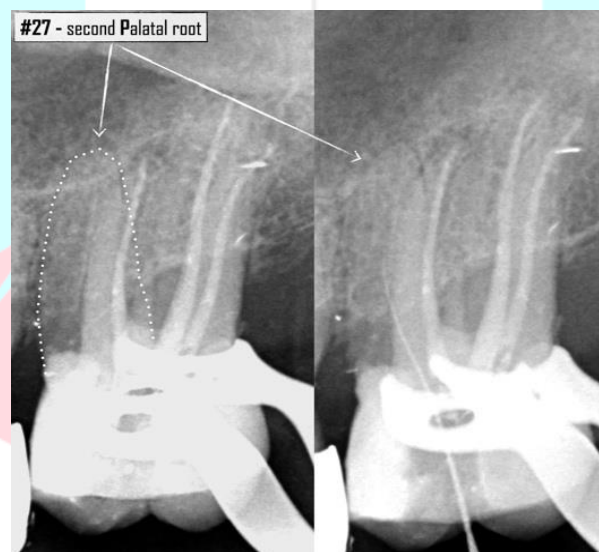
Radiographic assessment showing second palatal root and canal
